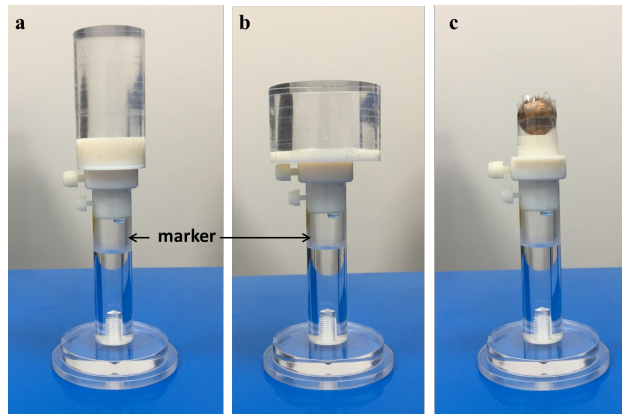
The versatility of the PRESAGE® sample holder to be placed in the QUASAR cylindrical insert. The sample holder was modified to have a cylindrical container of 2cm diameter and 2cm length. For these experiments, the container was filled with a liquid that provides good contrast for MR images (marker). The holder can be used to attach perspex cylinders or PRESAGE® samples with different shapes and sizes. (a) 3.5cm diameter; (b) 5.45cm diameter; (c) 2cm diameter copper sphere. This sphere was used for the determination of the MRI-linac latency.
